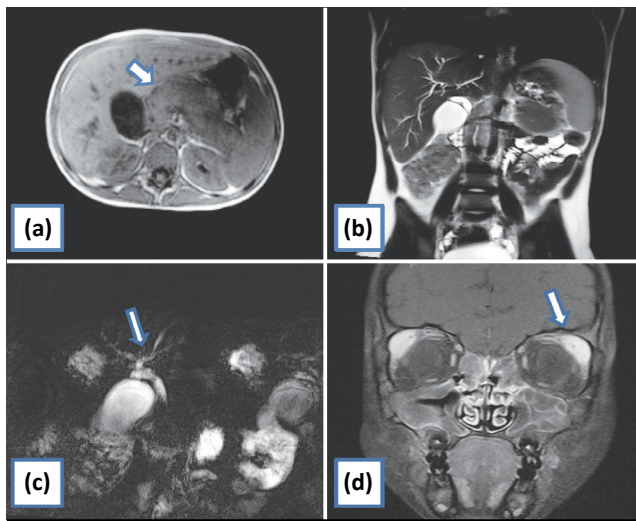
The magnetic resonance imaging and magnetic resonance cholangiopancreatography findings of the patient. (a) (T1W MRI) Diffuse enlargement of pancreas and capsule like rim. (b) (T2W MRI) Mild dilatation of intrahepatic bile ducts. (c) (MRCP) Narrowing at the bifurcation of the common hepatic duct. (d) (MRI) Enlarged lacrimal glands with contrast enhancement
